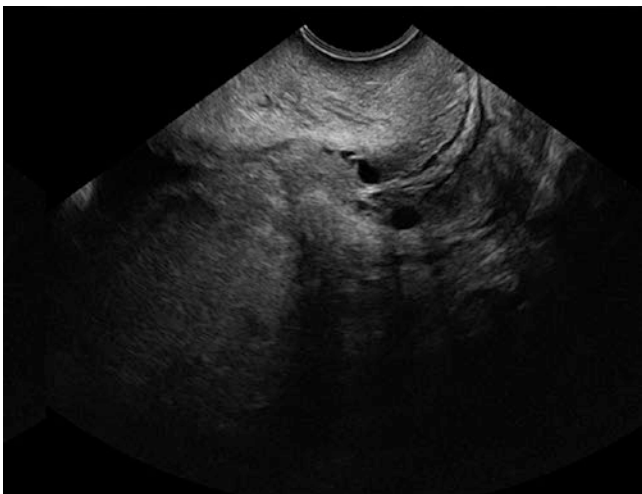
Transvaginal ultrasound at 20 weeks: the placental edge is found to be overlapping the internal cervical orifice
